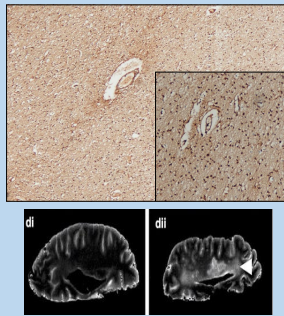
Image (top) shows example of fibrinogen leakage. Image (below) shows a WML as seen on an MRI scan.
